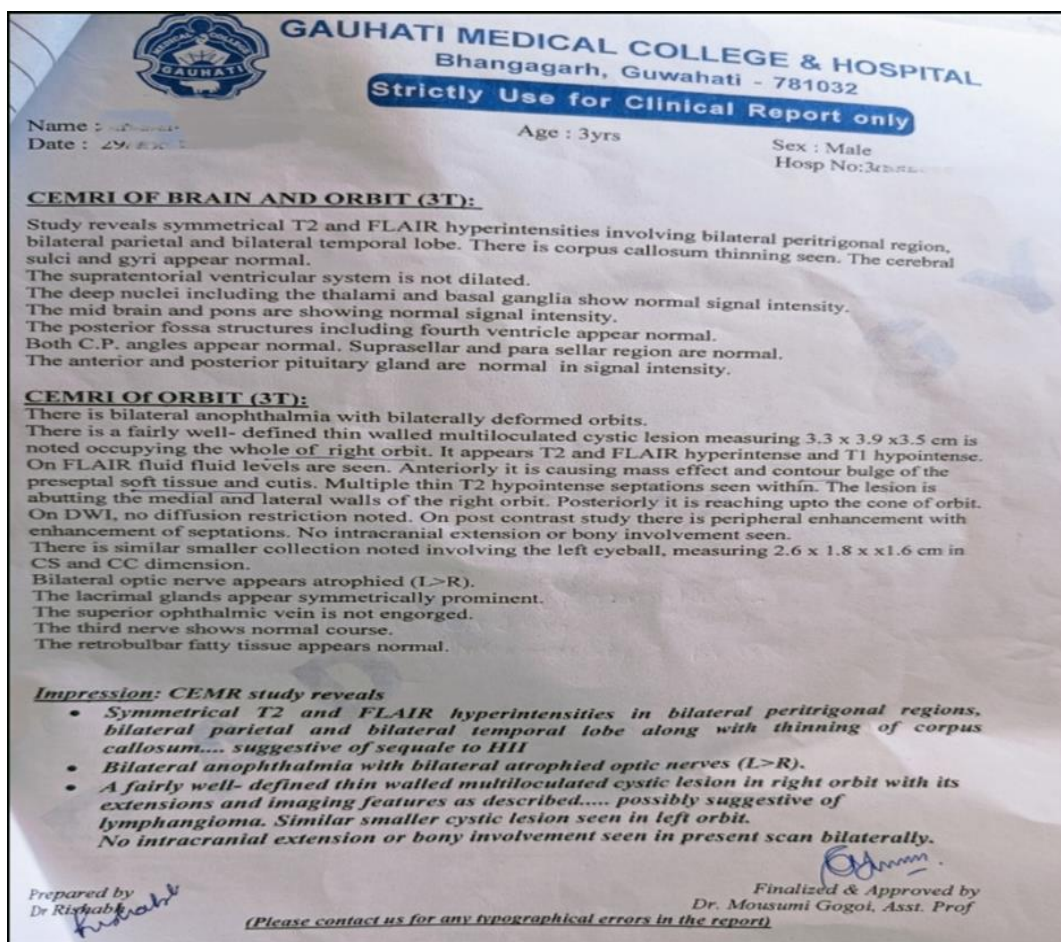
MRI report establishing anophthalmia both eye with lymphangioma Right orbit
